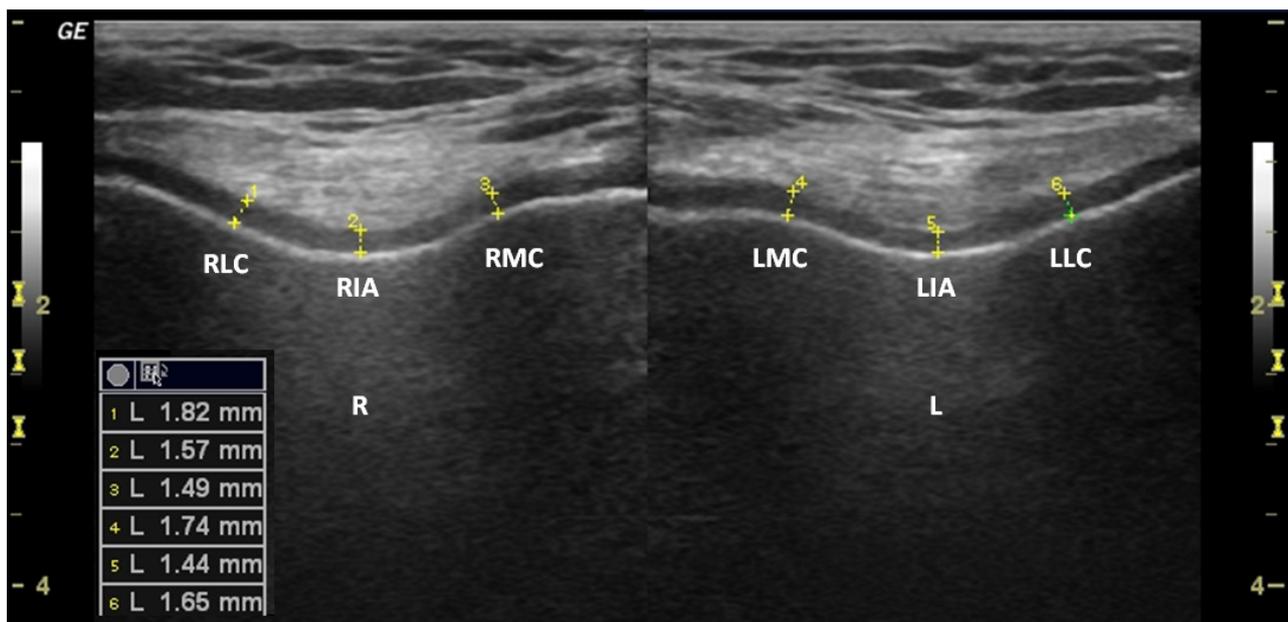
Suprapatellar axial view showing bilateral femoral distal cartilage measurements with ultrasonography. (RLC; right lateral condyle, RIA; right intercondylar area, RMC; right medial condyle, LMC; left medial condyle, LIA; left intercondylar area, LLC; left lateral condyle)
